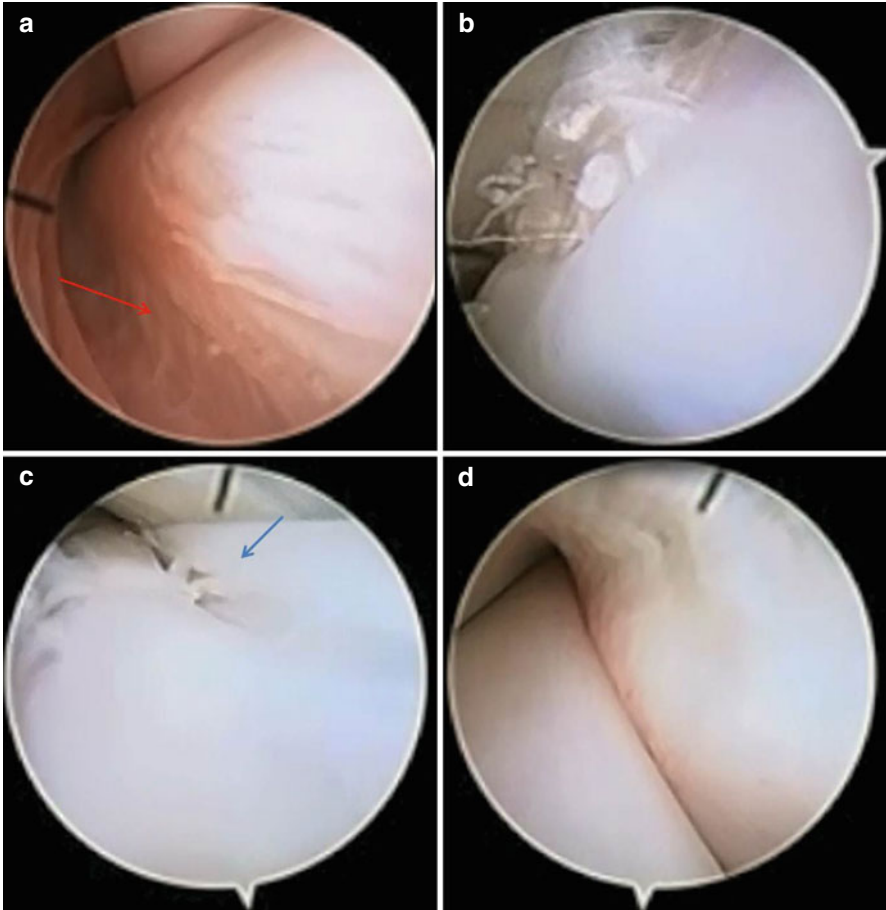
Peroneal tendoscopy showing both tendons and vincula (*red arrow – a*); rupture of peroneus brevis noticed (*b*); further inspection revealed a length rupture (*blue arrow – c*); notice the flattened aspect of the tendon on the right surrounding the tendon on the left bottom of the image (*d*) similarly to what was suggested in MRI of Fig. 20.1
